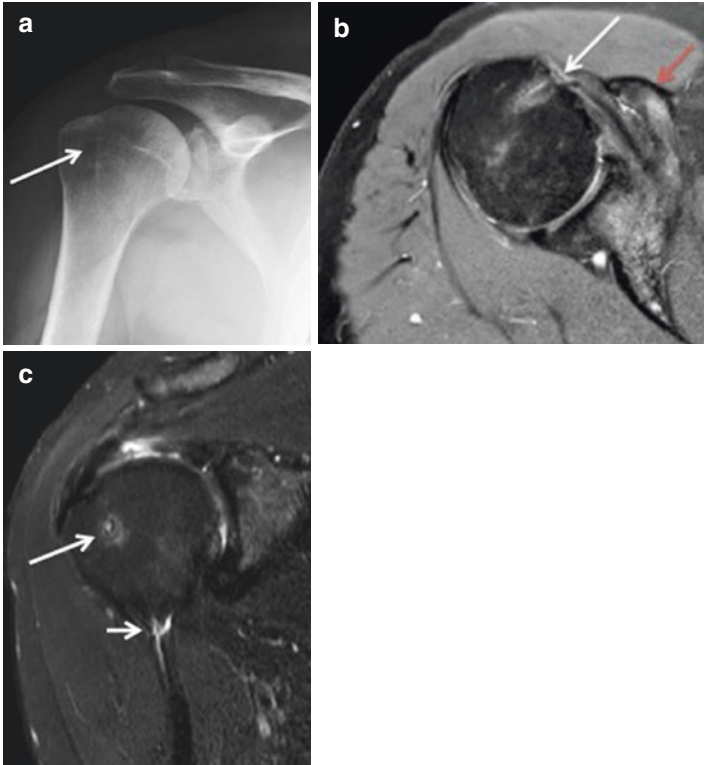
(a) AP radiograph of the right shoulder. Circular lucency shown by the *arrow* signifying placement of prior tenodesis within the bicipital groove. (b) T2 axial MRI demonstrating mild edema at the site of prior arthroscopic anchor insertion and within the groove (indicated by *white arrow*). The coracoid process (identified by *red arrow*) as well as the subscapularis muscle can be used as reference points for anatomical level consistent with midportion of the bicipital groove. (c) T2 coronal MRI showing the biceps tendon running superiorly (identified by *small arrow*) with area of surrounding edema. Also noted is continued edema at prior tenodesis site (*larger arrow*)
